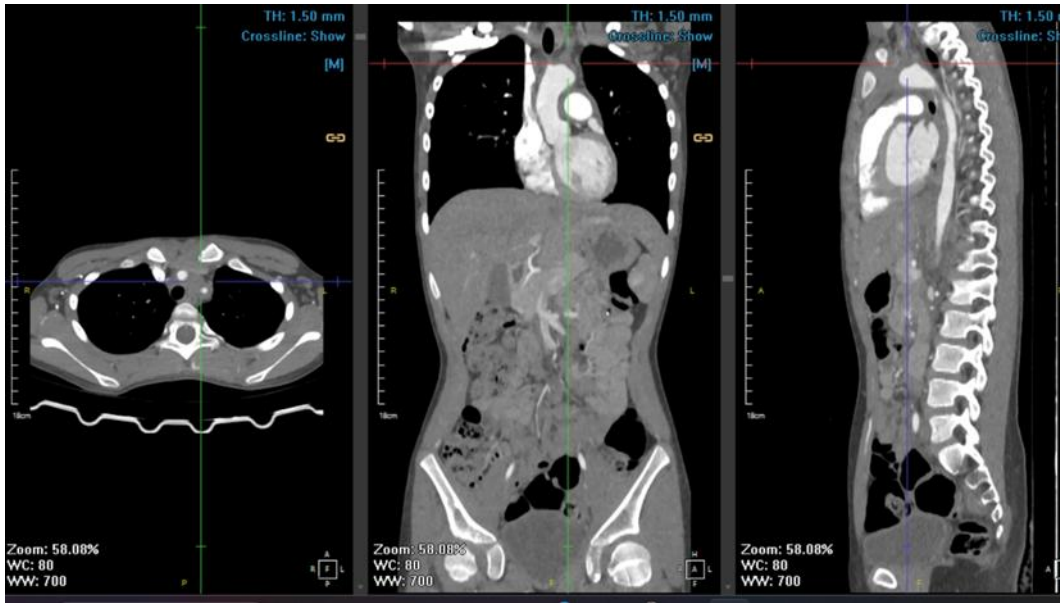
CT-scan Angiography Examination
